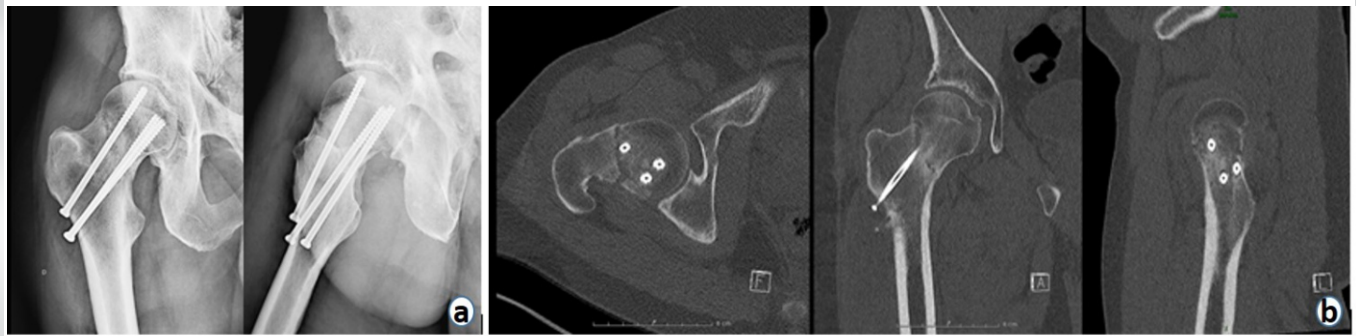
Non-union of the fracture site at 6 months of fracture fixation. (a) Frontal and profile X-rays at 6 months of the hip fracture screw fixation with persistent non-union. (b) Transversal, frontal, and sagittal Ct-scanner views demonstrating the non-union.
